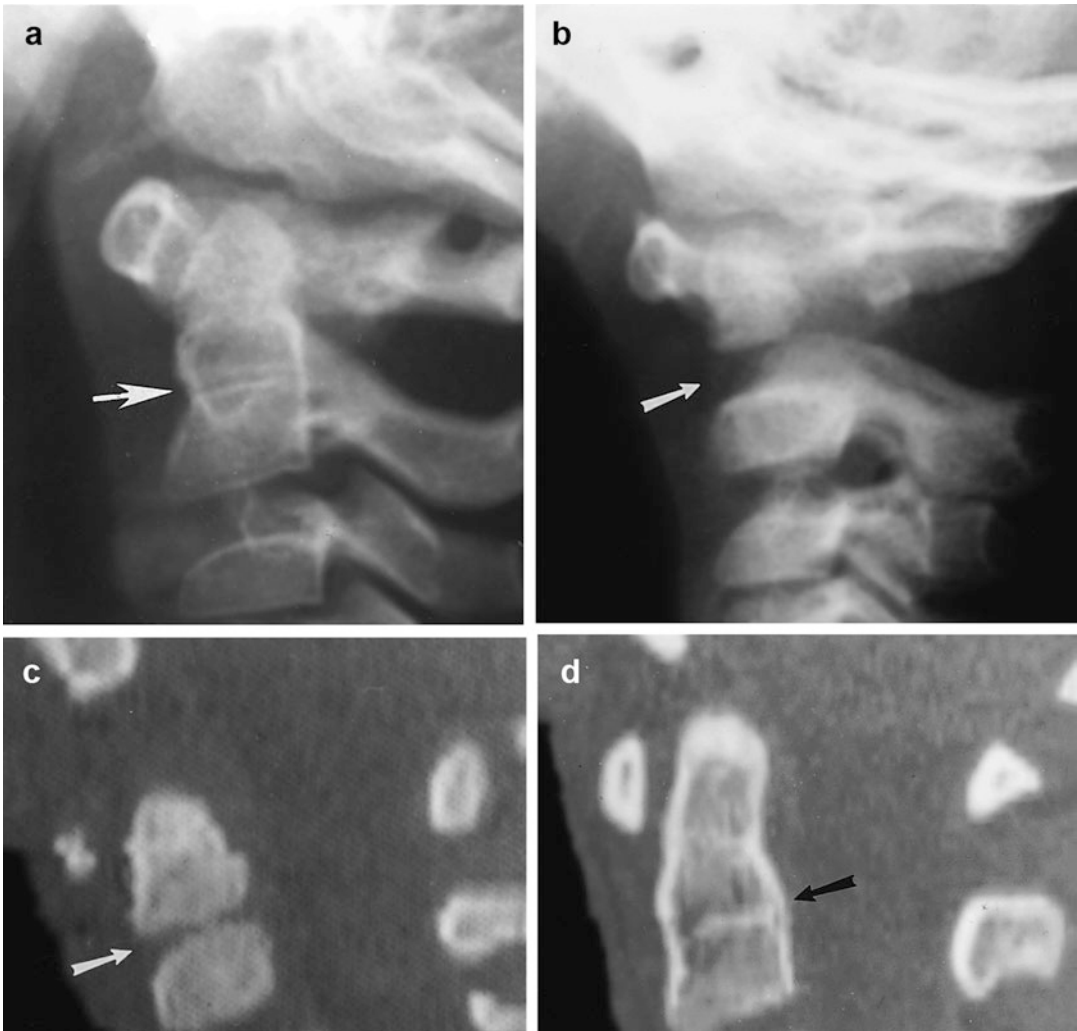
(a–d) Normal synchondrosis between the dens and the body of C2. (a) Note the typical radiolucent synchondrosis (arrow) between the dens and the body of C2. (b) Young infant with a very wide, and potentially confusing, but still normal synchondrosis (arrow) between the dens and the body of C2. (c) Sagittal reconstructed CT image demonstrates the normal synchondrosis (arrow) between
